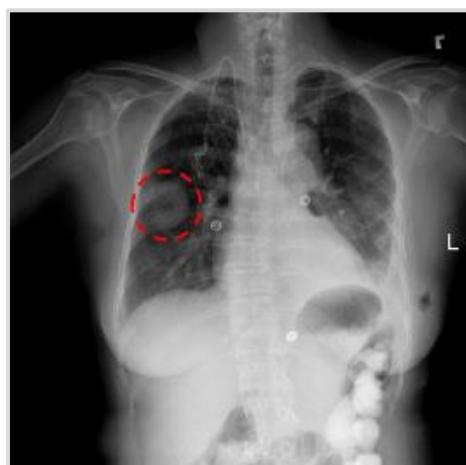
A chest x-ray identifies a lung mass.
